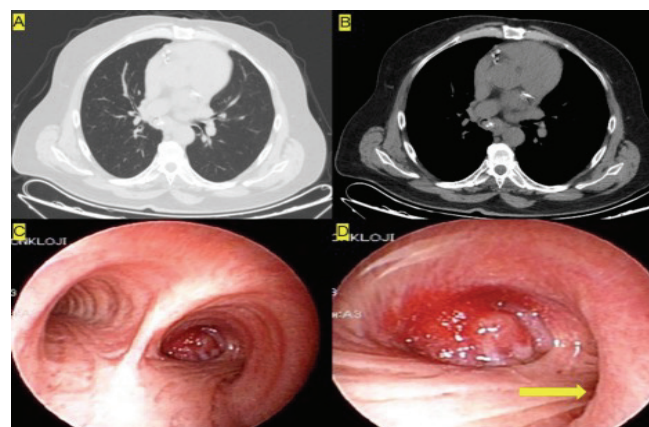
CT bronchoscopy and images of a lesion localized in the intermediate bronchus A: CT parenchymal section image of the lesion in the intermediate bronchus localization. B: Mediastinum section, C: FOB view of main bronchi, D: FOB image, yellow arrow, upper lobe entrance.
